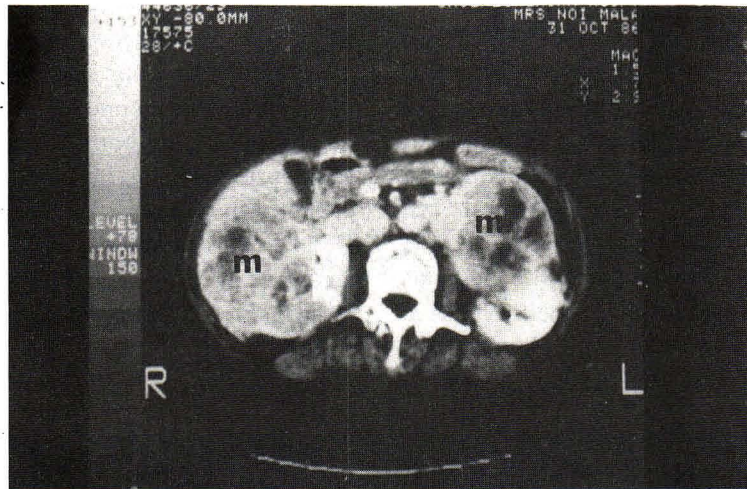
An enhanced axial CT scan shows inhomogenous enhanced masses in both kidneys (m) with rim enhancement.
